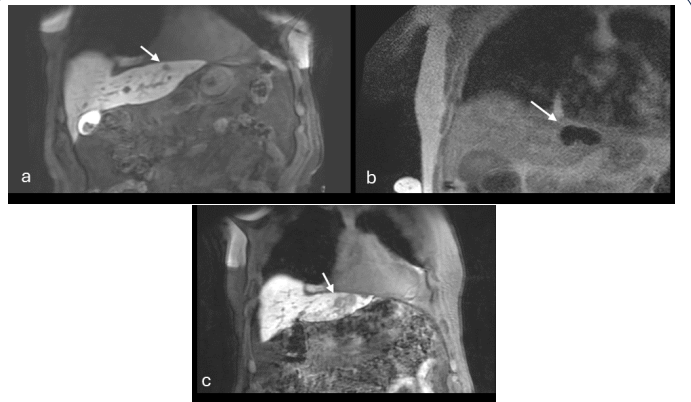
71-year-old male with rectal cancer metastasis in the right hepatic lobe, 6 mm from the cardiac structure. (a) Pre-procedural coronal contrast-enhanced T1-weighted MRI demonstrating the enhancing lesion (arrow) in the right lobe with the cardiac silhouette visible superiorly. (b) Intraprocedural coronal T2-weighted MRI demonstrating the hypointense iceball (arrow) with preserved T2 signal between the ablation zone and the cardiac border. (c) Follow-up coronal contrast-enhanced T1-weighted MRI demonstrating a non-enhancing ablation zone (arrow) without residual tumor; no in-field progression.
